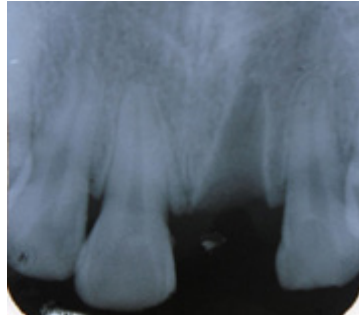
Preoperative intraoral radiograph showing empty alveolar socket
